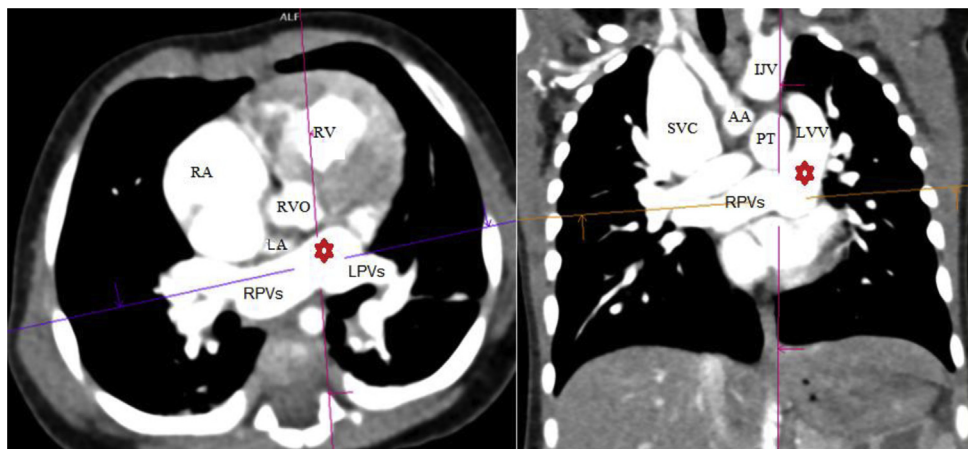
Axial (right) and coronal (left) postcontrast computed tomography sections: the right pulmonary veins (RPVs) and left pulmonary veins (LPVs) join all together posterior to the left atrium (LA) and left ventricular outlet (LVO). The confluence of PVs (red star) converges into a large left vertical vein (LVV) that is ascending lateral to the pulmonary trunk (PT). The superior vena cava (SVC), right atrium (RA), right ventricle (RV), and even left internal jugular vein (IJV) are dilated. The pulmonary trunk (PT) is prominent compared to the ascending aorta (AA) at the same level.
